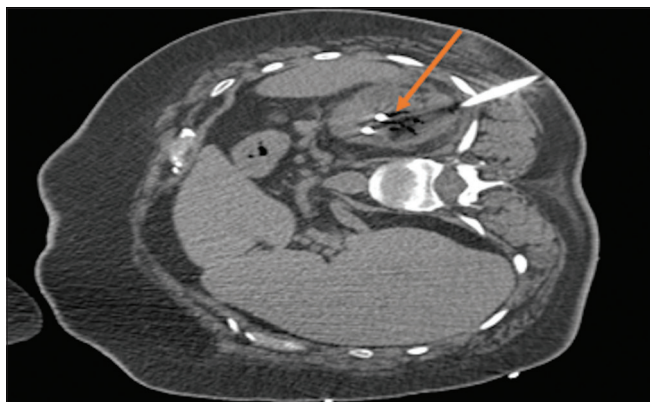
A 60-year-old woman with diabetes who presented with flank pain, dysuria, and confusion, undergoing percutaneous nephrostomy tube placement for emphysematous pyelonephritis. CT obtained during drain placement procedure shows catheter placement (arrow) in the above-noted gas and fluid collection in the left kidney.
